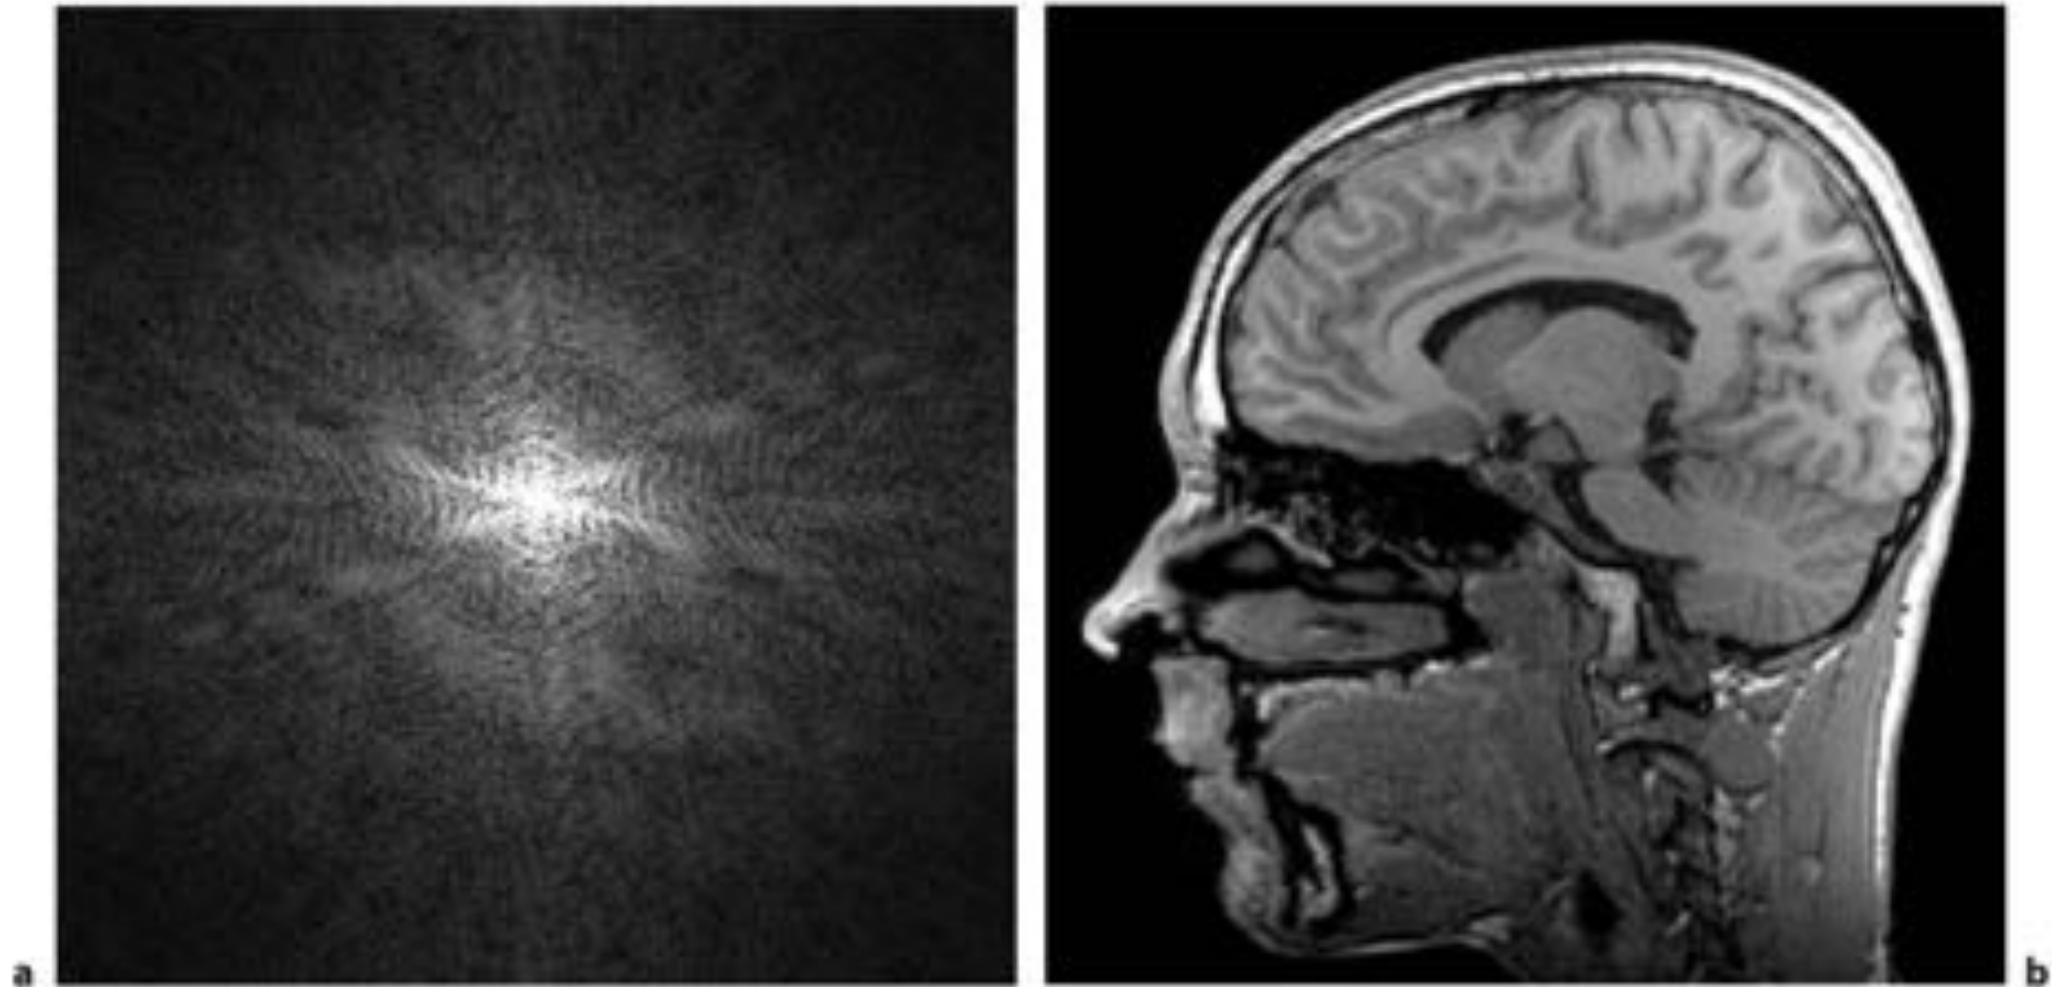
a Raw data in k-space (magnitude presentation of complex data) and b corresponding reconstructed MR image. Highest intensities in k-space are found in the center, corresponding to slowly varying image intensities in b.
